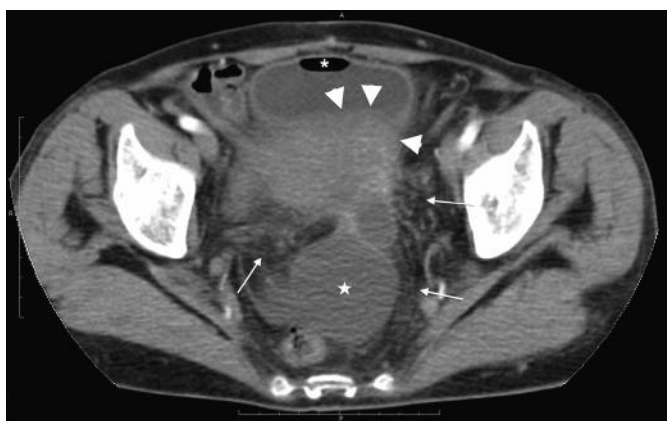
Y – CT axial slice showing the bowel-bladder thickened walls (arrowheads) with consensual surrounding adipose tissue effusion (arrows). Air-fluid level is clearly evident inside the bladder (asterisk) and reactive fluid trasudate inside the Douglas pouch (star).
